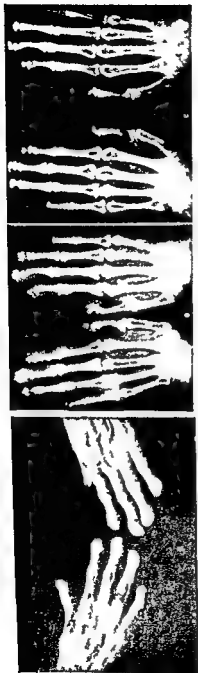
HYPERPARATHYROIDISM. Clubbing of the fingers in hyperparathyroidism due to decalcification of the terminal phalanx is shown in X-ray (left) which is recalcification as shown in the further X-ray (right) taken nine months after removal of a parathyroid tumour. (By courtesy of Dr. A. H. Gutman *J. Amer. Med. Ass.* (1934), cm 8.)
